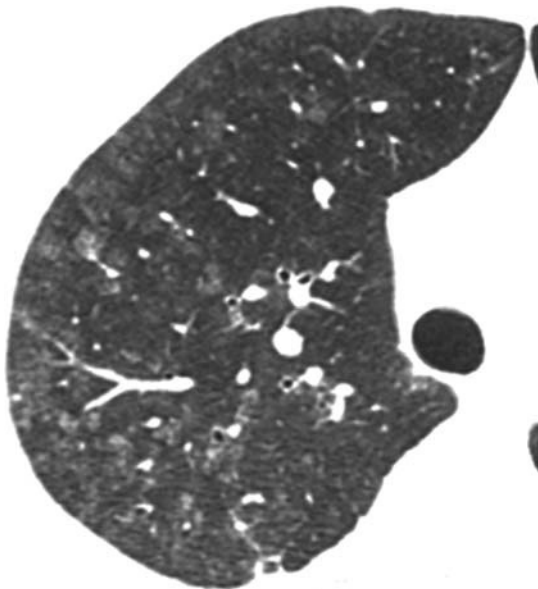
A 48-year-old man with leptospirosis. Computed tomography shows bilateral ground-glass opacities involving mainly the peripheral regions of both lungs.
